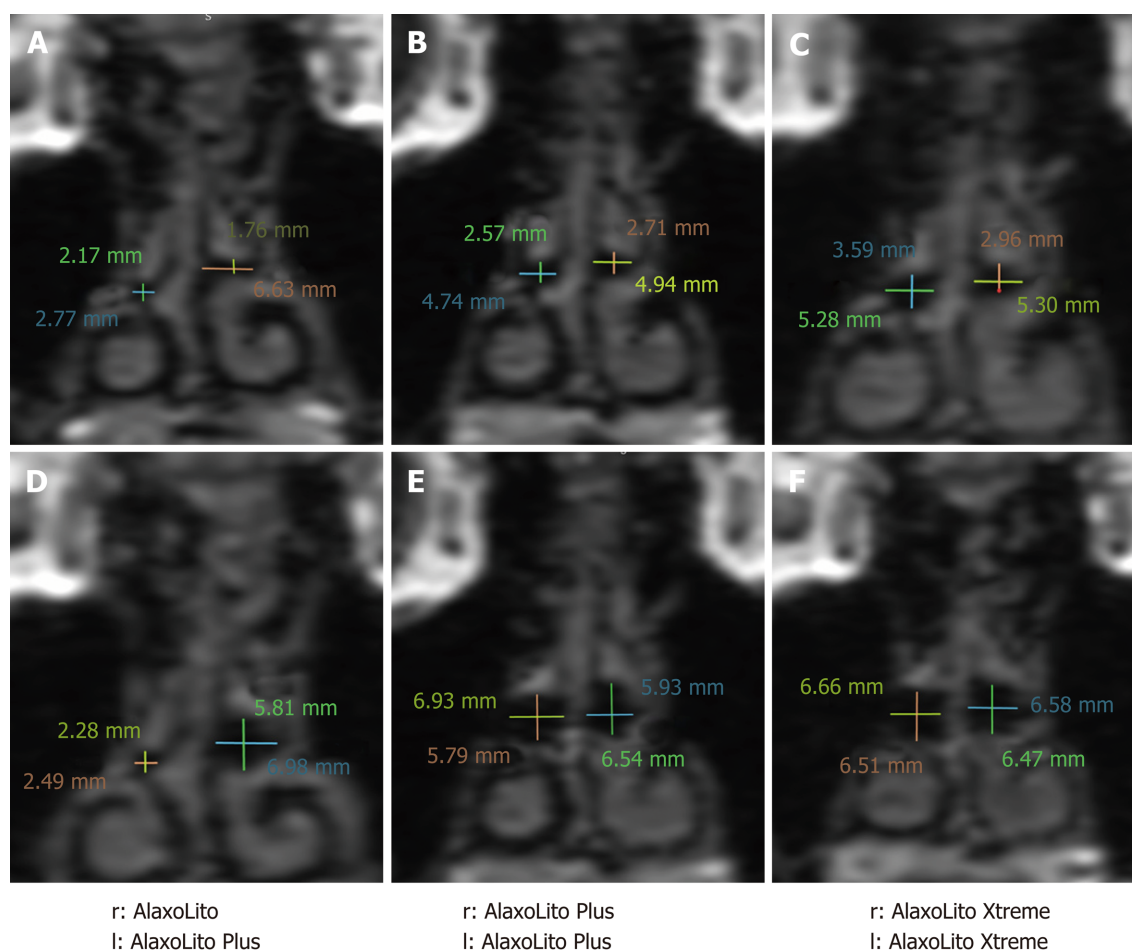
Coronal magnetic resonance imaging showing measurements of middle nasal passage without stents (A-C) and with stents *in situ* (D-F). A and D: Magnetic resonance imaging (MRI) from December 2015 prior to regular use of stents; B and E: MRI from June 2017 one year post regular use of AlaxoLito Plus; C and F: MRI from September 2018, 3.5 mo post regular use of AlaxoLito Xtreme.
